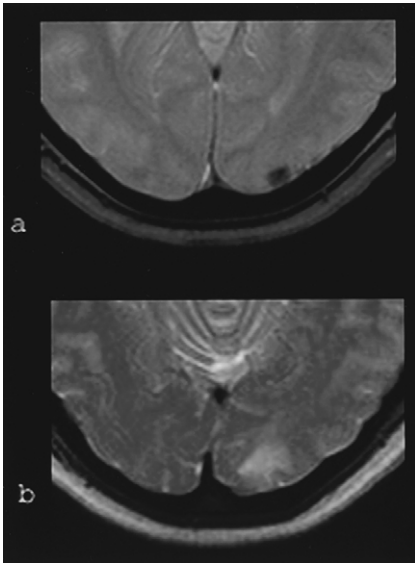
Central nervous system vasculitis. Small hemorrhagic lesion in the left occipital cortex/subcortical region. Note that it is difficult to recognize the hemorrhagic nature of the lesion on the fast spin-echo T2-weighted image (b) without the gradient-echo image (a).
